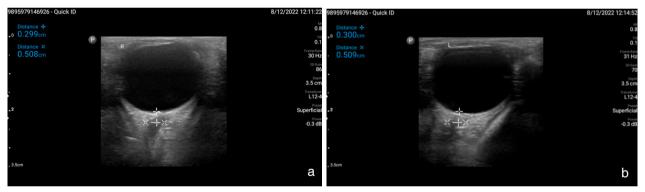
Periorbital ultrasound of left and right eyes with increased ICP a. ONSD Ocular Dextra (ONSD OD), b. ONSD Ocular Sinistra (ONSD OS)
